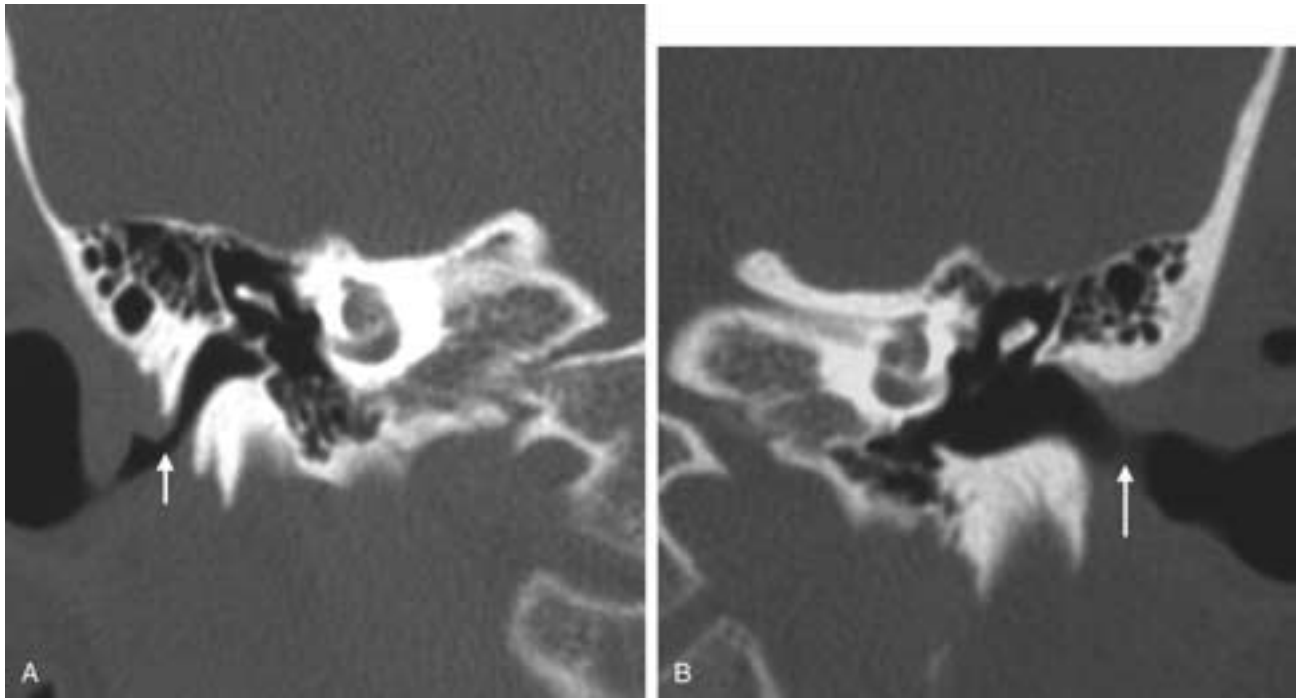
EAC stenosis. A, Coronal CT image at the level of the body of the incus showing stenosis of the right EAC. B, Coronal CT image at the same level as A on the opposite side showing a normal EAC without stenosis.
